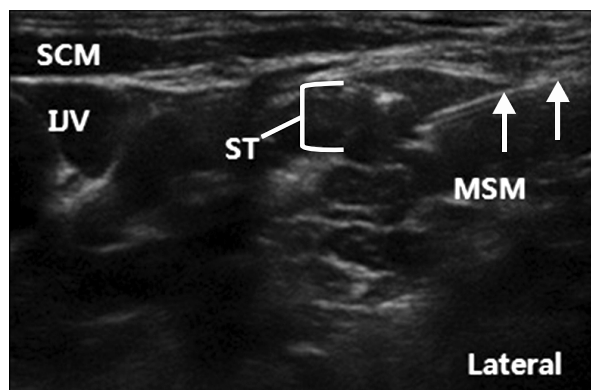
Ultrasound image showing low approach interscalene brachial plexus block. Needle pathway (arrows), SCM: sternocleidomastoid muscle, IJV: internal jugular vein, ST: superior trunk of brachial plexus, MSM: middle scalene muscle.
